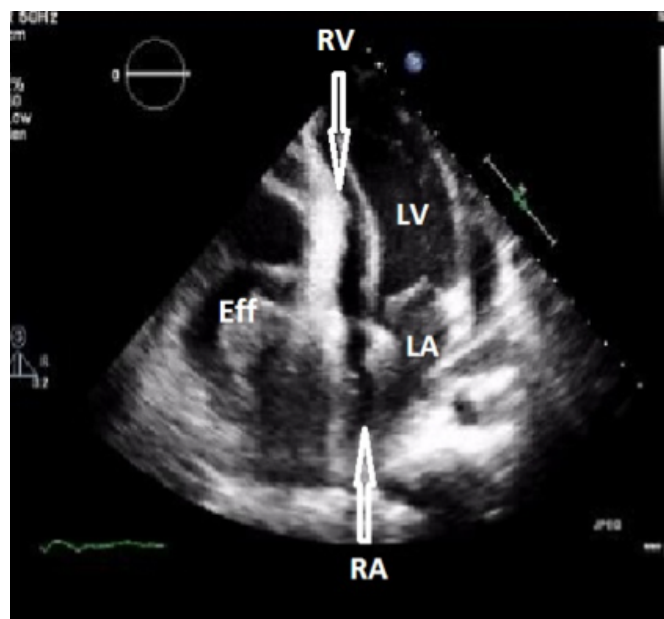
Pericardial effusion caused compression in both the right atrium and ventricle. 4-cavity transesophageal echocardiographic image. LV= Left Ventricle, LA= Left Atrium, RA= Right Atrium, RV= Right Ventricle, Eff= pericardial effusion
